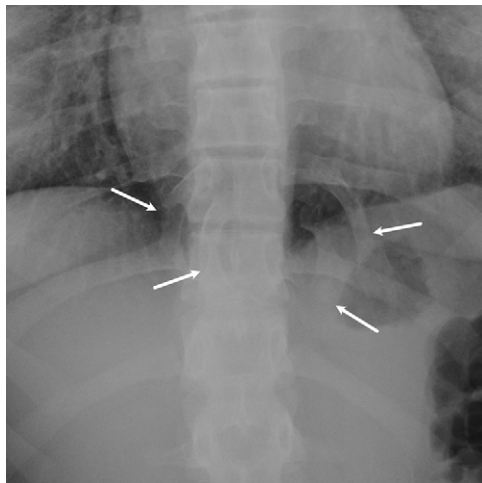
Intrathoracic ribs in a 16-year-old adolescent girl. Frontal radiograph shows bilateral supernumerary ribs (arrows) that arise from bilateral 10th costovertebral junctions and extend inferiorly.
